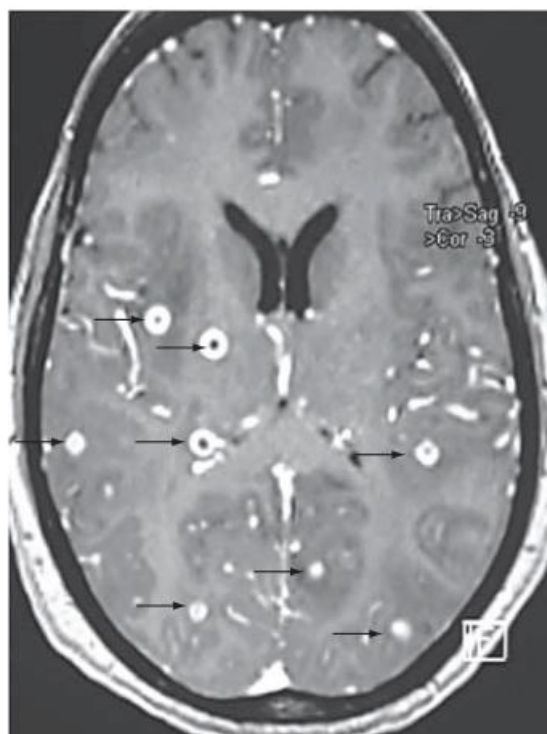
Neurocysticercosis. T2-weighted axial image of the brain showing multiple lesions of neurocysticercosis (large arrows show the largest lesions).
